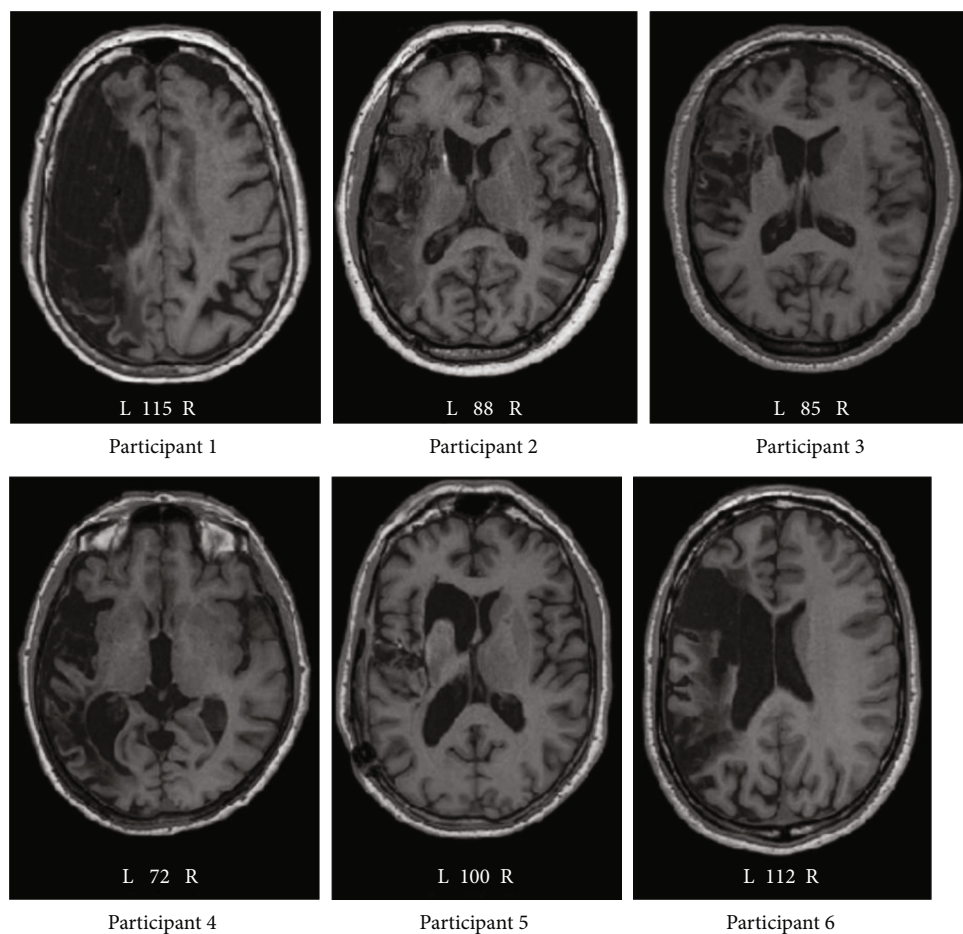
Brain MRI scans (axial plane) of the participants. Key: L: left hemisphere; R: right hemisphere; numbers indicate serial axial slice images.
